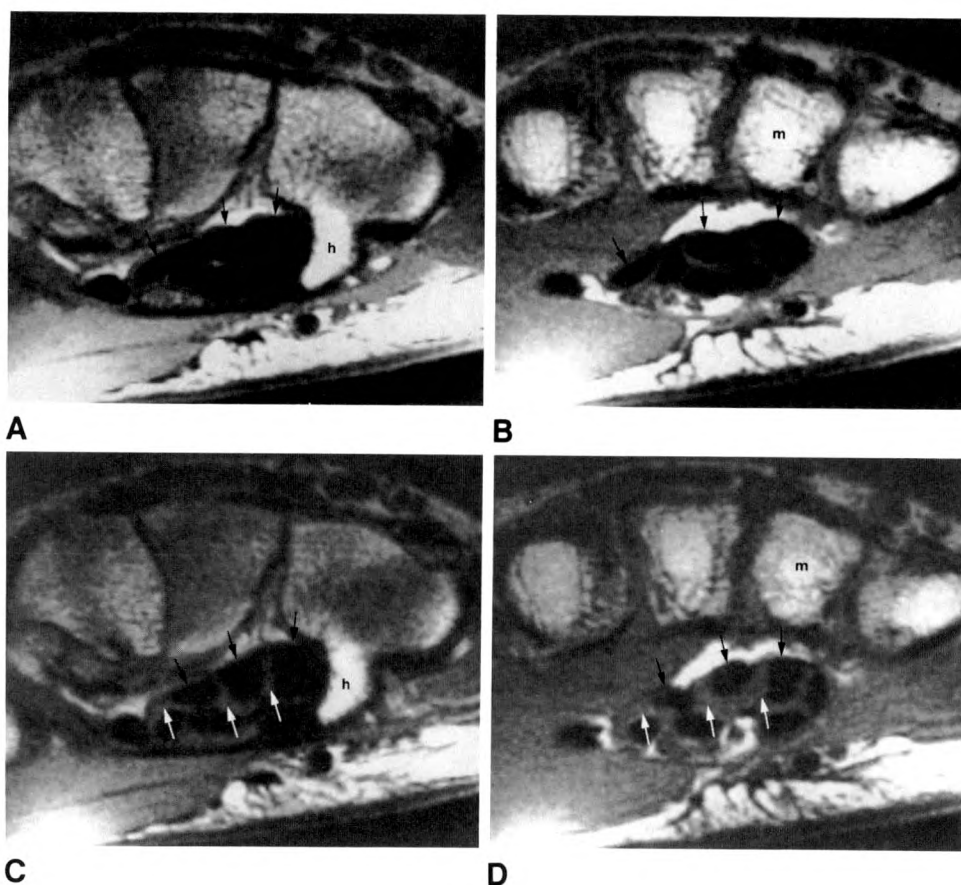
Proximal migration of lumbricals with finger flexion. Left wrist viewed toward elbow with palm down. Axial MR images (TR 600, TE 25) at level of hook of hamate (h) and metacarpal bases (m). White arrows indicate lumbrical muscles; black arrows show deep flexor tendons.
